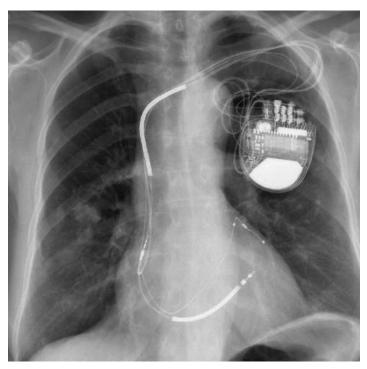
An anteroposterior chest X-ray view displaying the left ventricular quadripolar lead placed in an anterior coronary vein together with the standard right ventricular (RV) pacing-defibrillating lead placed at the RV septum and the right atrial lead placed at the right atrial appendage, and the CRT-D device in the left infra-clavicular area.
